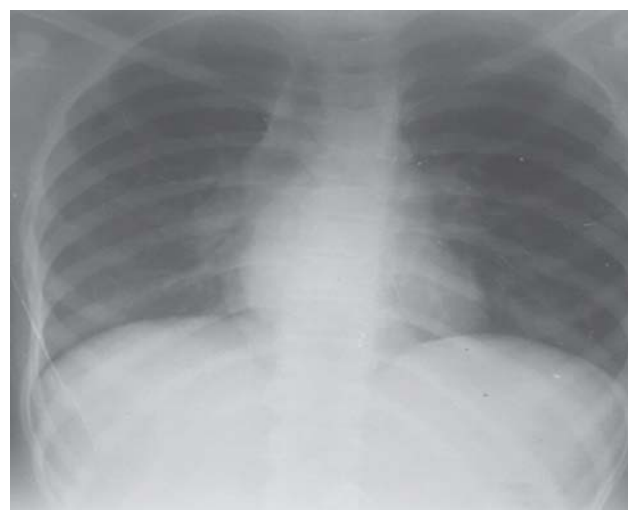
Chest radiograph (postero-anterior view) showing bilateral hilar prominence and infiltrates in the right lung field.
